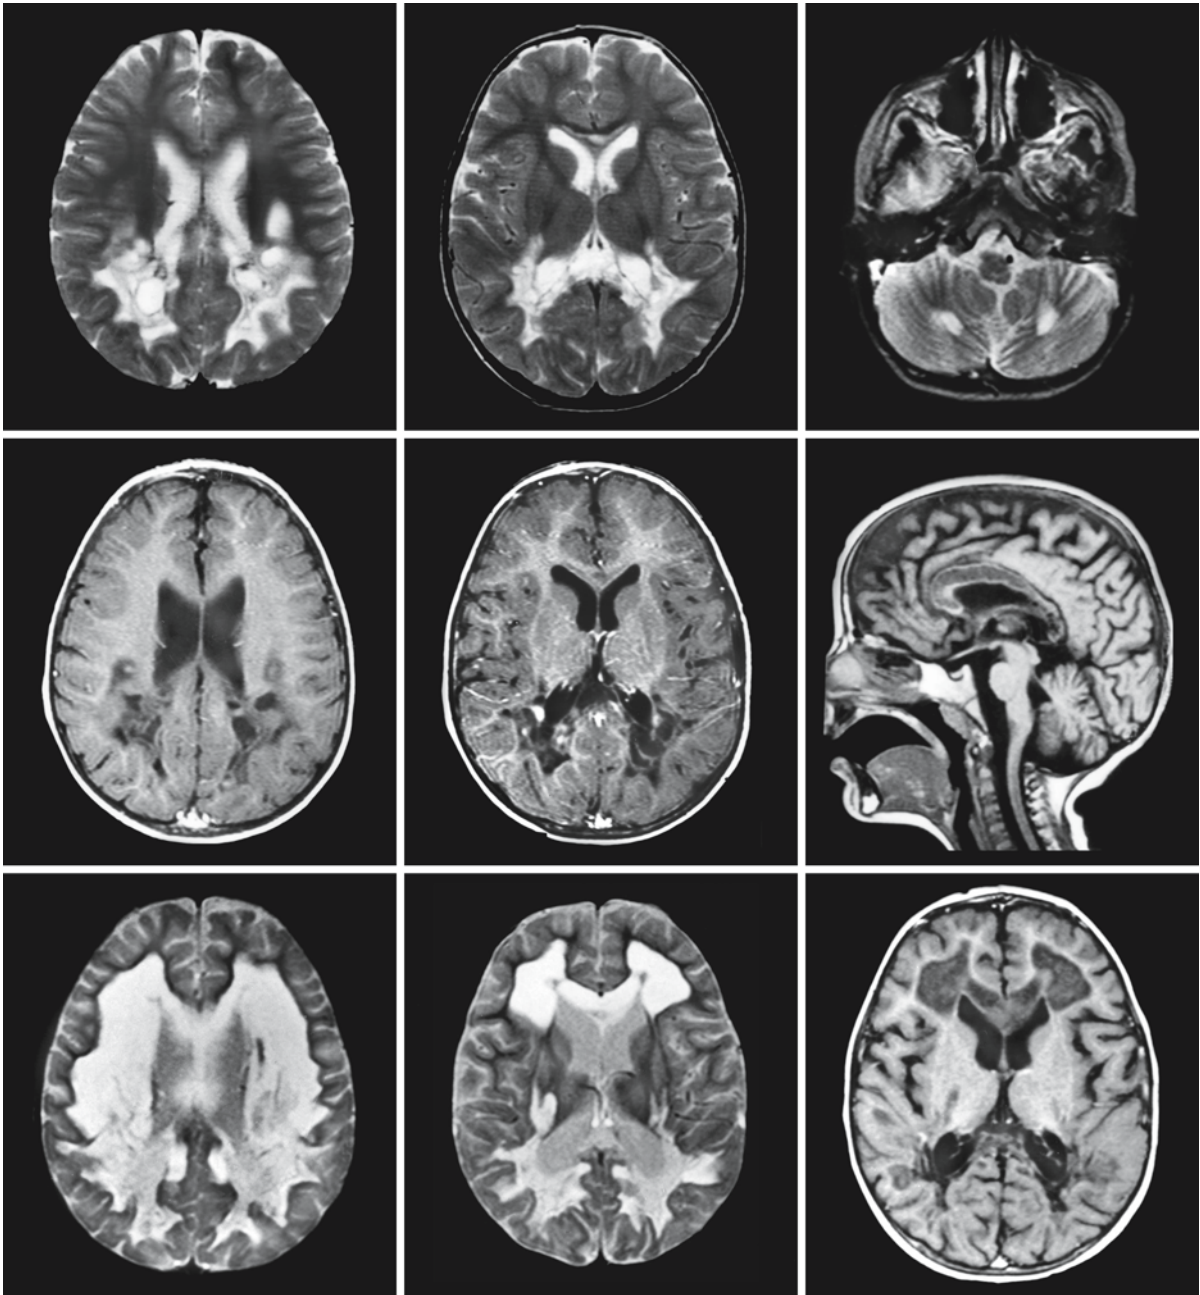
Boy with isolated complex I deficiency. The first MRI (*first row; second row, left and middle*) was obtained at presentation at 3 years of age. Note the extensive signal abnormalities in the posterior cerebral white matter and posterior part of the corpus callosum. The abnormal white matter is partially cystic. There are foci of contrast enhancement within the abnormal white matter (*second row, middle*). The cerebellar
